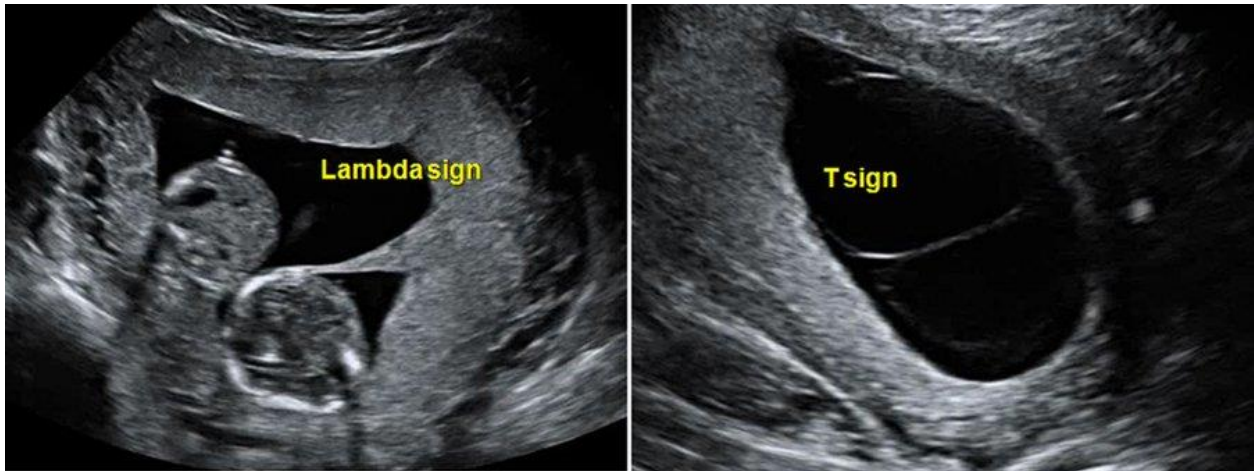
“Lambda” and “T” sign in ultrasound diagnostics of chorionicity
